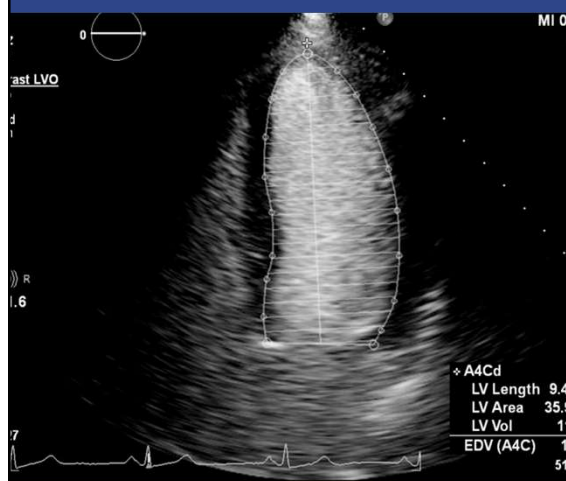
UEA apical 4 EDV image from author's clinical collection, de-identified (M.Trump, 2025)
